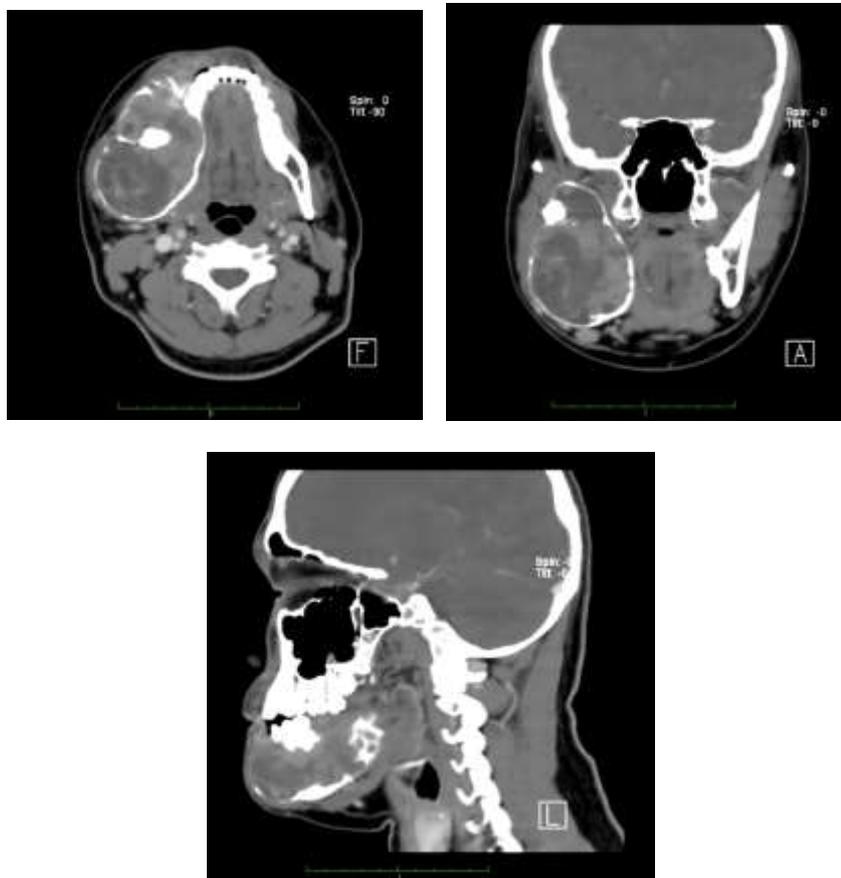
CT Scan revealed a very large well-defined radiolucent expansile lesion in the right body and ramus of the mandible with multilocular appearance causing expansion of the body and ramus.
